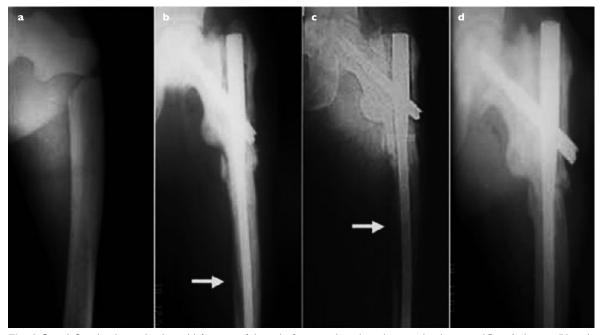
I Case I. Serial radiographs show: (a) fracture of the right femur at the subtrochanteric level in typical Paget's disease; (b) early osteolysis distal to the fracture at four weeks following surgery; (c) massive osteolysis ($12 \text{ cm} \times 4 \text{ cm}$) at seven weeks follow-up; (d) bony union of fracture at 20 weeks with complete reversal of osteolysis.
